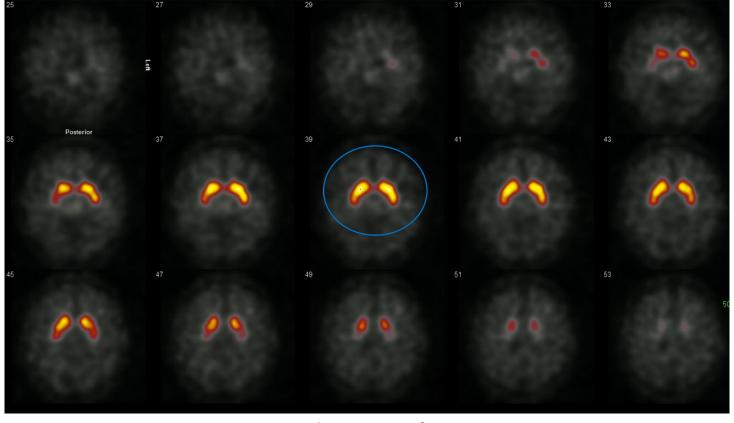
Axial SPECT images from DaT Scan
